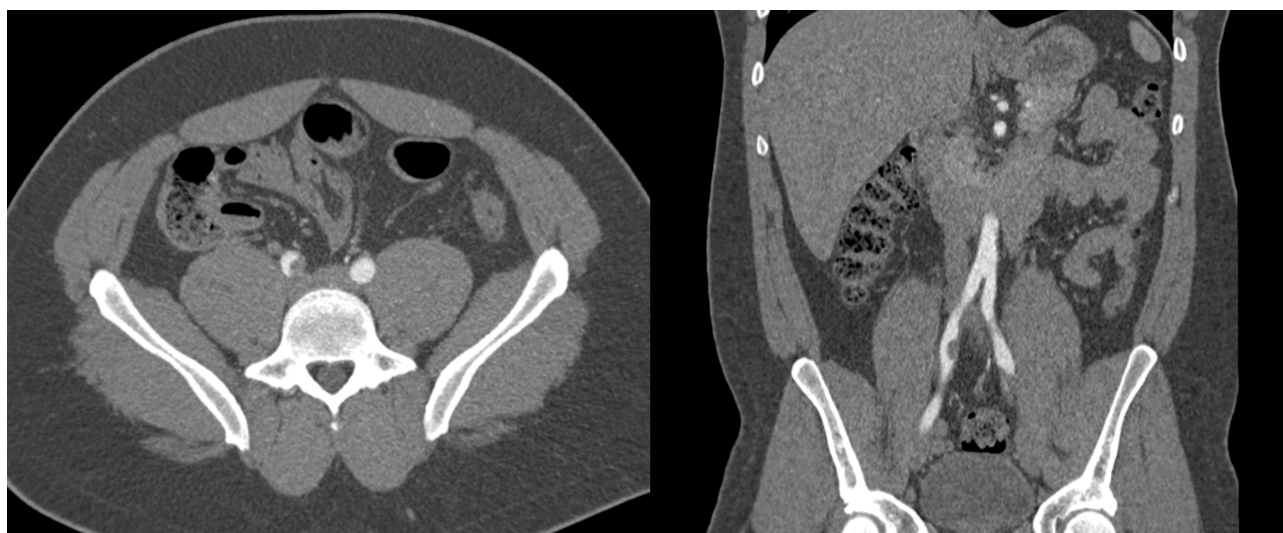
CT images in the transverse and coronal plane showing eccentric partial thrombosis at the level of the right distal common iliac artery.
